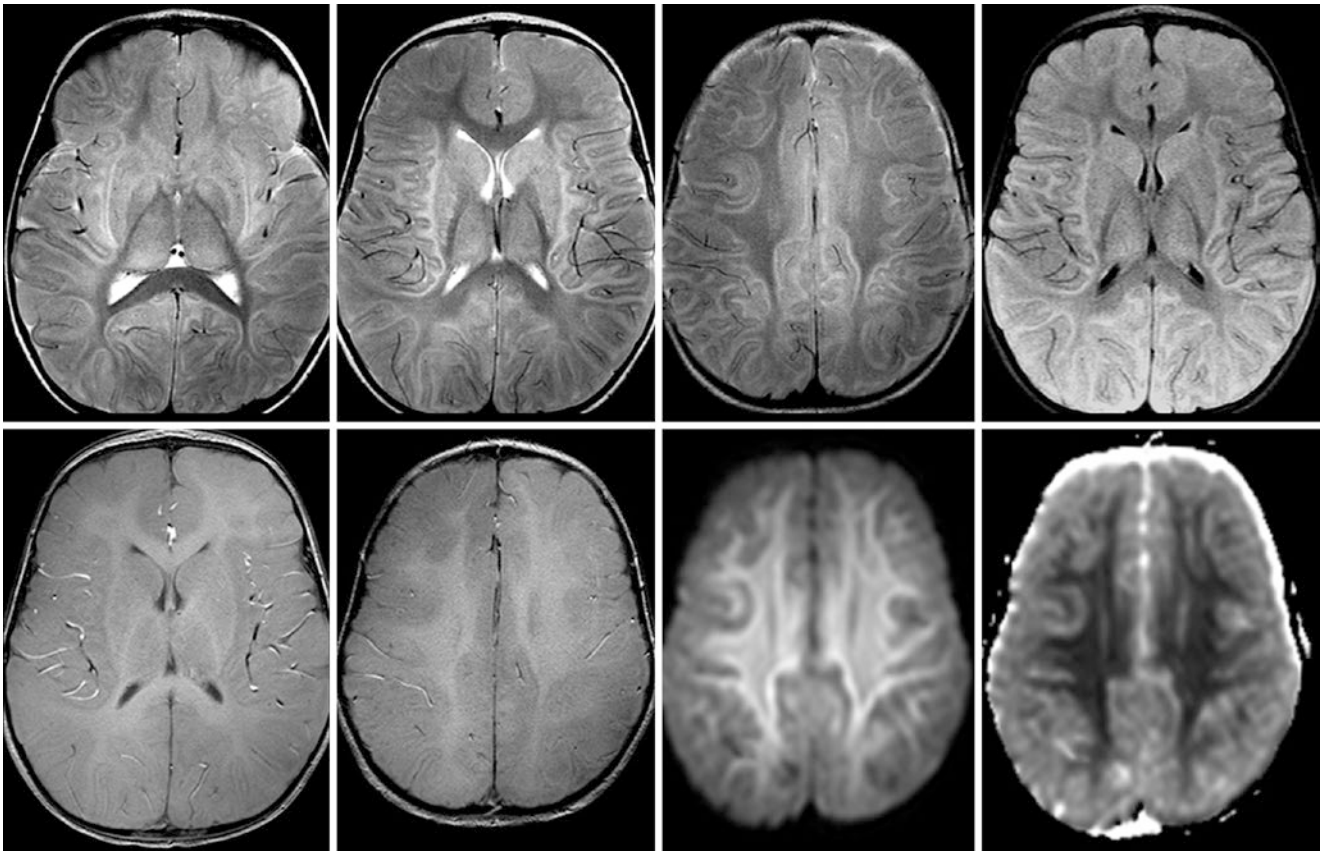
Comparison case of subacute hypoxic-ischemic injury (HII). A 7-month-old remained unresponsive 8 days after a prolonged seizure from a febrile illness. A 3T MRI demonstrated diffuse hyperintensity of the cortex and basal ganglia on SE T2WIs (top, left three images) and on FLAIR (top, right). GE T1WIs (bottom, left two images)
